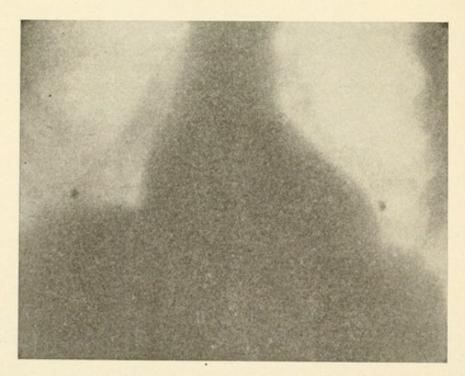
After a half-hour's exercise, with mild resistance. (X-ray photograph of heart.)
